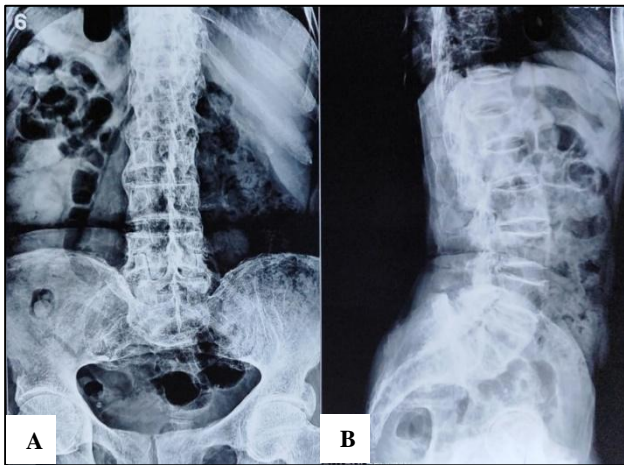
(A and B): X-ray.
